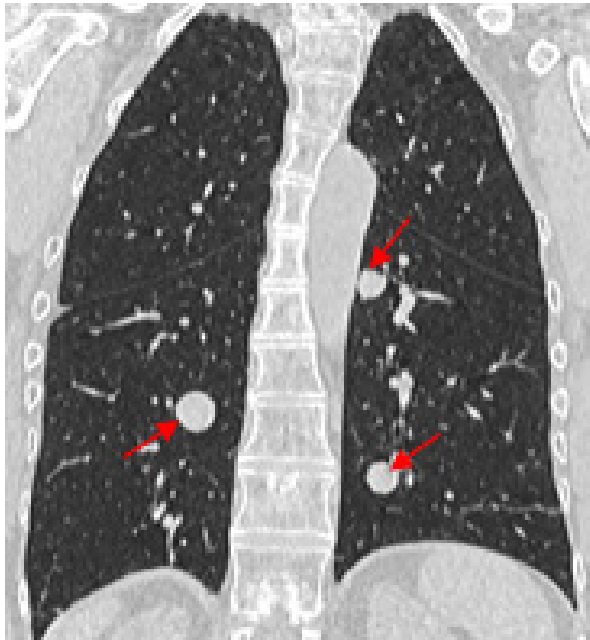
Coronal pulmonary CT image showing multiple well defined lung metastasis from FTC (arrows)
